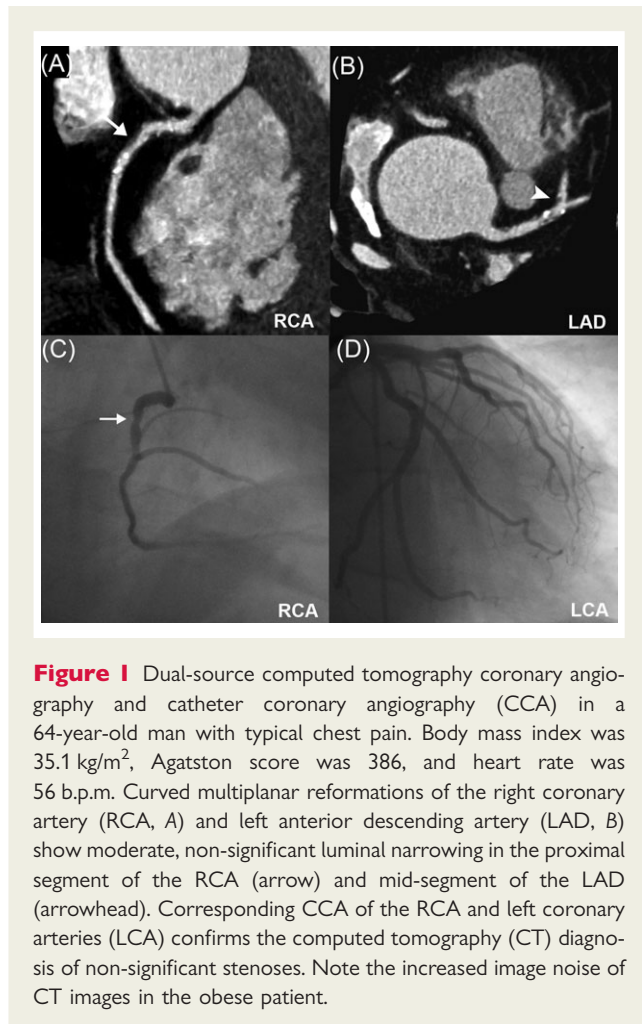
Dual-source computed tomography coronary angiography and catheter coronary angiography (CCA) in a 64-year-old man with typical chest pain. Body mass index was 35.1 kg/m², Agatston score was 386, and heart rate was 56 b.p.m. Curved multiplanar reformations of the right coronary artery (RCA, A) and left anterior descending artery (LAD, B) show moderate, non-significant luminal narrowing in the proximal segment of the RCA (arrow) and mid-segment of the LAD (arrowhead). Corresponding CCA of the RCA and left coronary arteries (LCA) confirms the computed tomography (CT) diagnosis of non-significant stenoses. Note the increased image noise of CT images in the obese patient.
